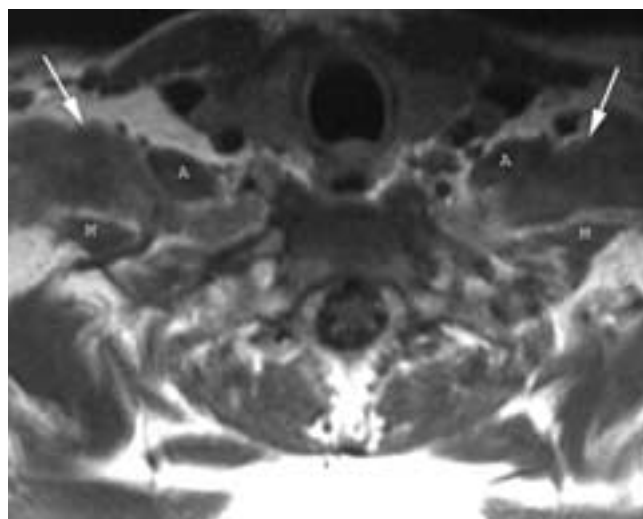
Neurofibromatosis. Axial T1-weighted MR image shows bilateral circumscribed intermediate signal intensity lesions (*arrows*) between the anterior (*A*) and middle (*M*) scalene muscles.
